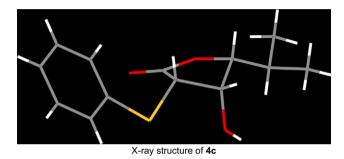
X-ray structures of lactones 4a, 4b, and 4c.
